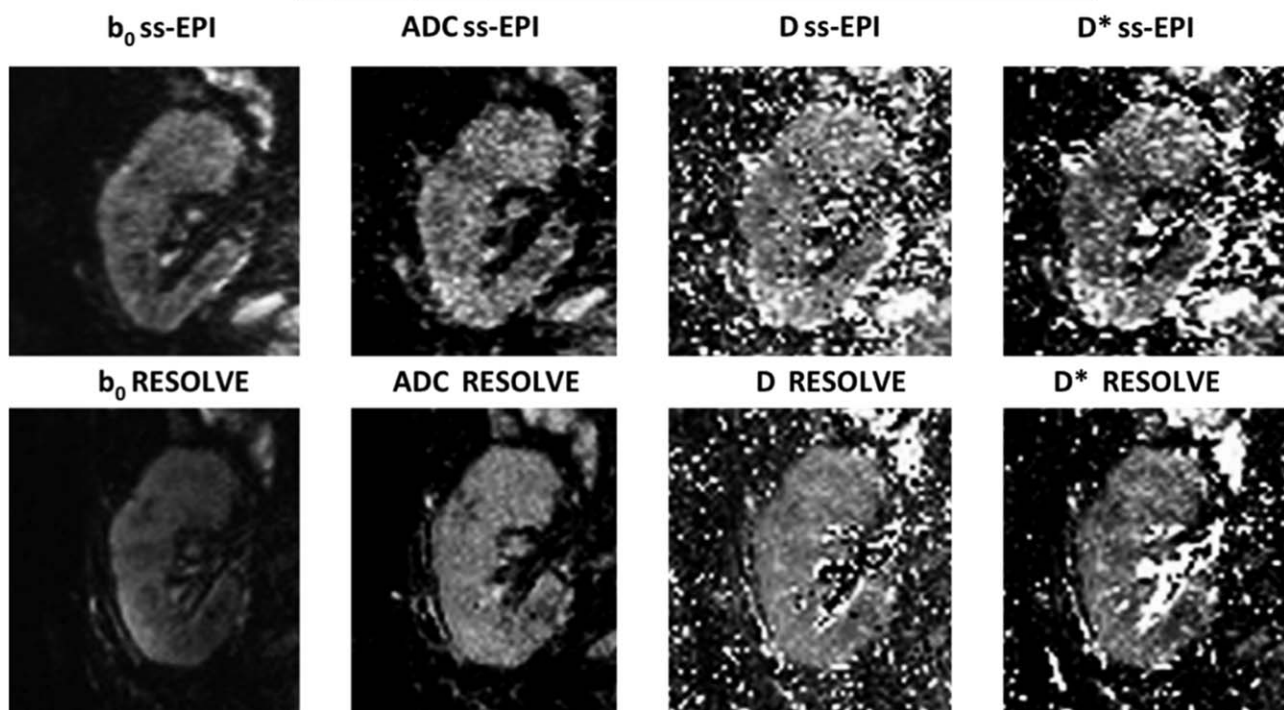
Example of coronal MR images ( $b_0$ , ADC, D, and  $D^*$  maps) of the right kidney of (A) a 26-year-old female healthy volunteer and of (B) an 83-year-old allograft patient with 30% interstitial fibrosis. First row are images obtained from the ss-EPI sequence and the second row are those obtained with the RESOLVE sequence. Cortico medullary differences were visible in healthy volunteer but disappeared in CKD with 30% of fibrosis DWI maps.
